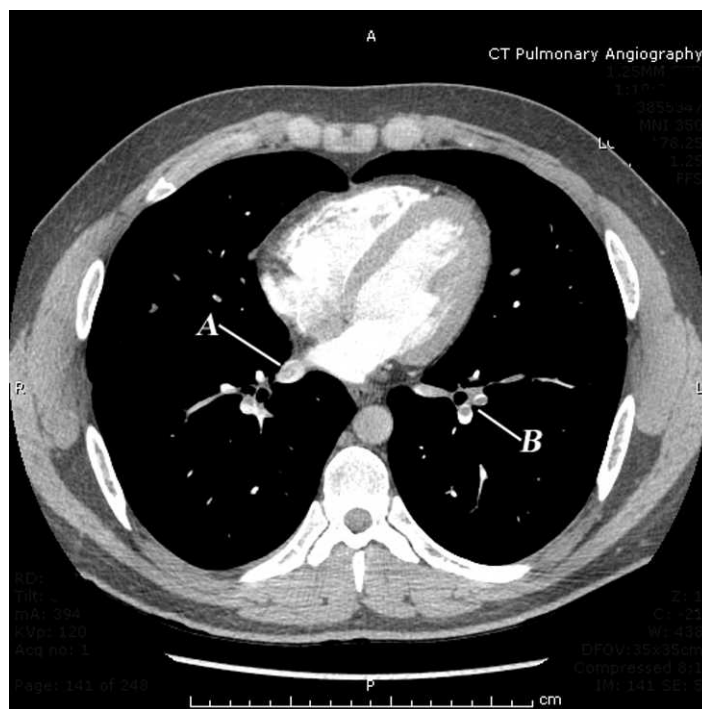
Axial section from the computed tomographic pulmonary angiogram demonstrating, A, filling defect in the right inferior pulmonary vein, in addition to, B, pulmonary emboli on the left.
